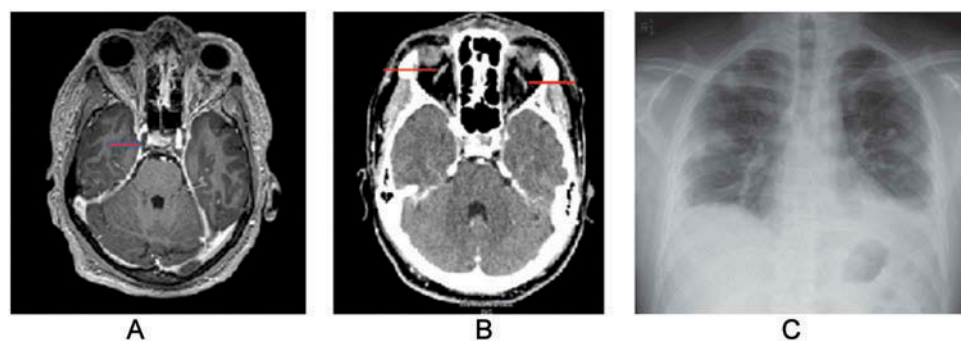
(A) Brain MRI (T1-weighted with gadolinium) showing non-opacification of the right cavernous sinus. (B) Contrast-enhanced brain CT showing bilateral engorged thrombosed superior ophthalmic veins. (C) Chest X ray showing multiple opacities in the lungs and left-sided pleural effusion.
